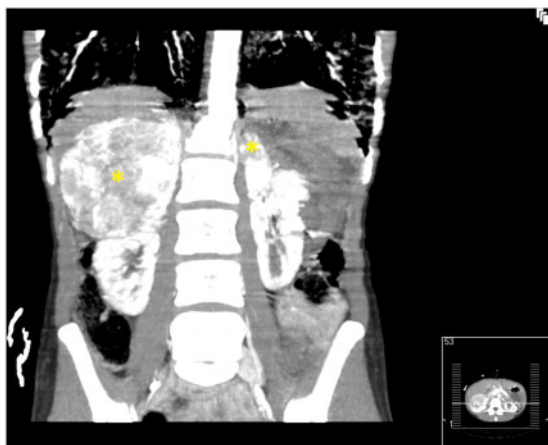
Computed tomography scan showing two heterogeneous solid masses (*), on the right (9.2 × 9.2 × 10.8 cm) and left (2.3 × 2.8 × 3.3 cm) adrenal gland.
